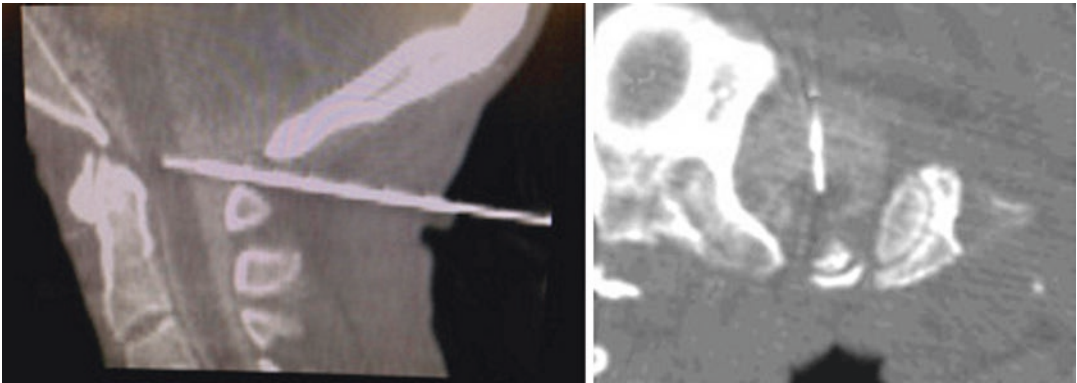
Sagittal interoperative CT of posterior approach occiput-C1 percutaneous radiofrequency myelotomy. Note the trajectory and depth of the spinal needle and radiofrequency electrode (left). The midline
